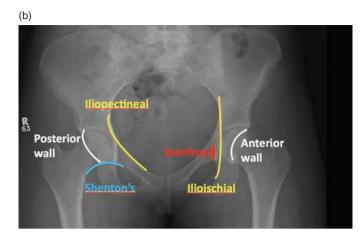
(a) AP pelvis radiograph. (b) Radiographic lines on AP pelvis
